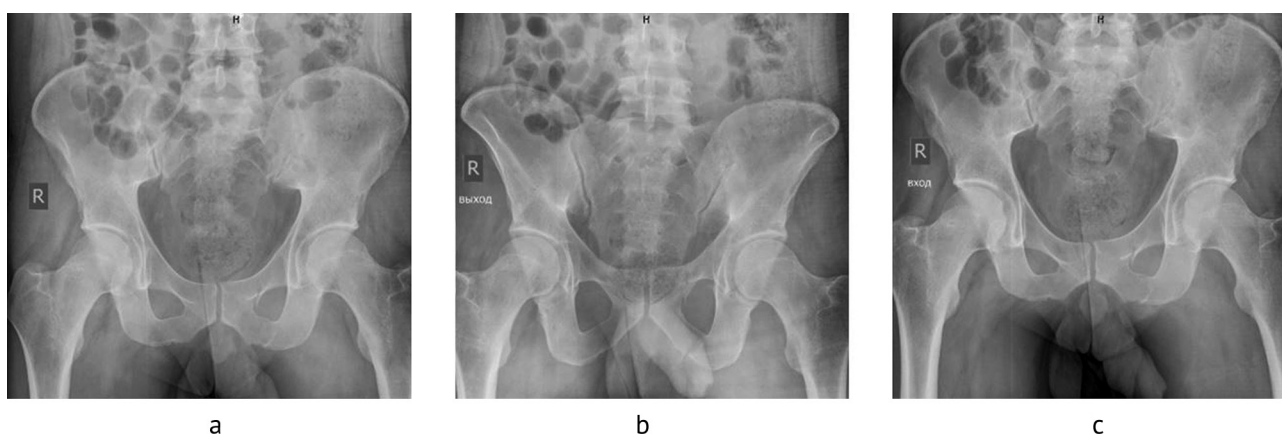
Radiographs of the pelvis upon admission: *a* — plain view; *b* — inlet projection; *c* — outlet projection
